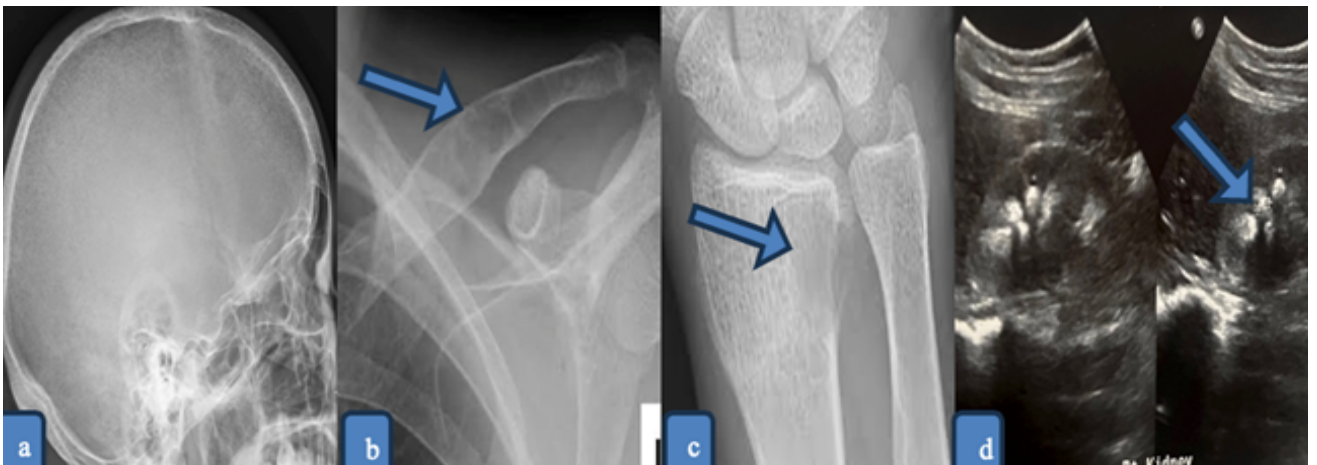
Skull radiograph lateral view(a) showing multiple tiny osteolytic lesions giving classical appearance of pepper pot skull. Expansile lytic lesion in left clavicle without bony erosion(b) Subcortical lytic lesion in medial aspect of radius(c) USG abdomen(d) showing bilateral nephrolithiasis.
